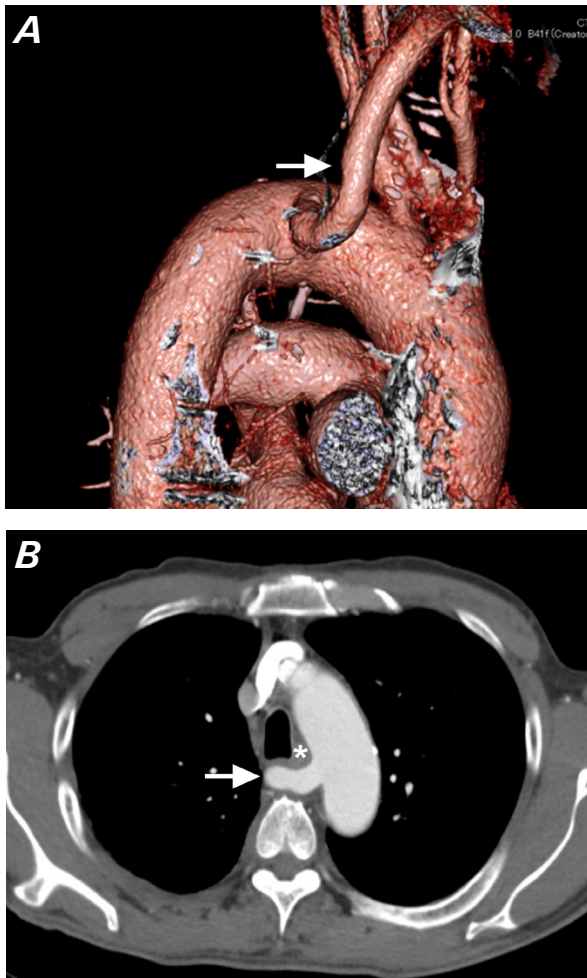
Preoperative computed tomographic angiograms in A) 3-dimensional reconstruction and B) axial views show a nonaneurysmal aberrant right subclavian artery (arrow). In B, note the nonaneurysmal artery coursing posterior to the esophagus (asterisk).
